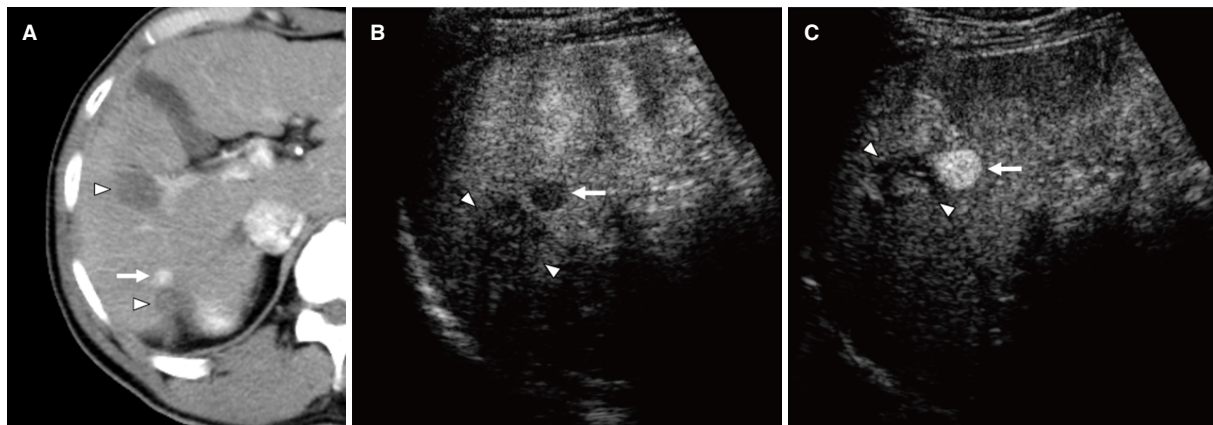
Defect reperfusion imaging for the local progression of hepatocellular carcinoma (HCC) after radiofrequency ablation (RFA). A: a computed tomography image shows focal arterial enhancement of the local progression of HCC (arrow) and RFA-induced coagulation necrosis (arrow heads); B: viable HCC (arrow) in close proximity to the necrotic area (arrow heads) are shown as areas with defects in the Kupffer phase; C: recurrent HCC (arrow) is clearly identified using the Sonazoid reinjection technique, whereas the necrotic area (arrow heads) does not enhance
